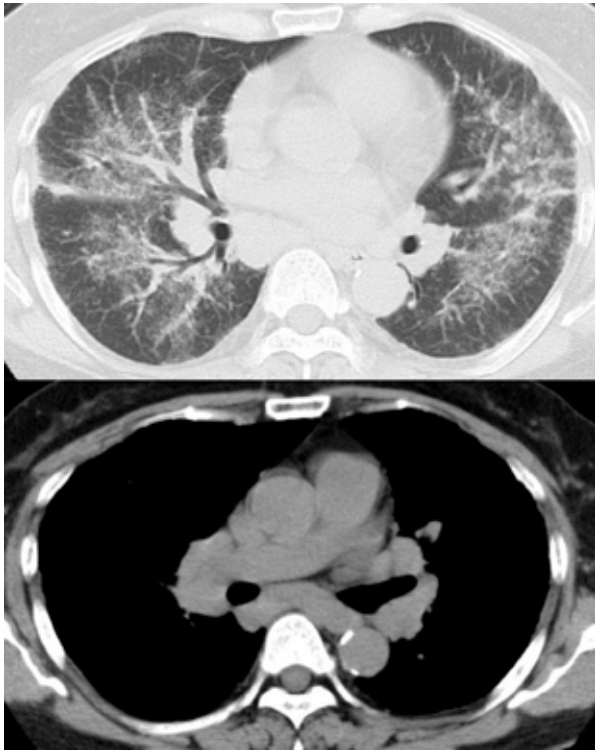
Chest CT showing ground glass opacities with small nodules, bronchial wall thickness in bilateral lung fields, and hilar and mediastinal lymph node swelling.
